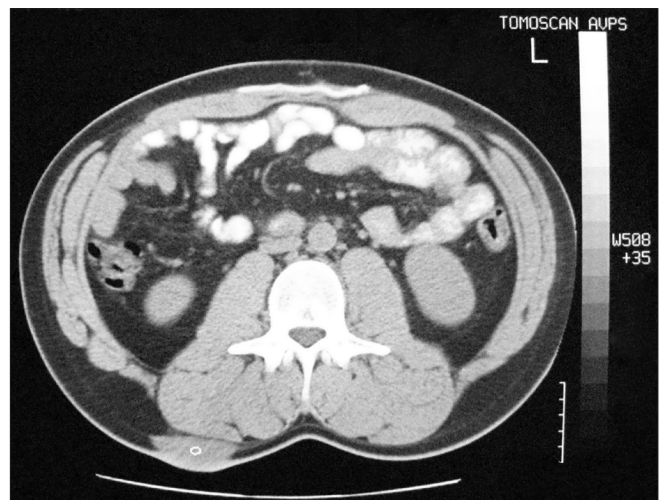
CT scan demonstrating a 5 × 3 × 3 cm subcutaneous lesion located in the right lumbar region laterally to L3
